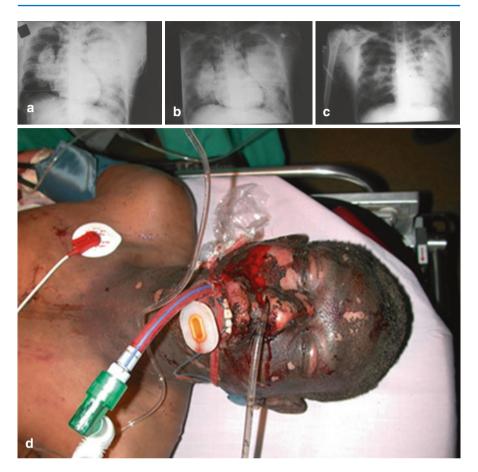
Chest X-rays of a 21-year-old border policeman show development of blast lung injury $(\mathbf{a}-\mathbf{c})$. The man identified a terrorist at the entrance to a hospital and hugged him in order to prevent him entering. The border policeman blew up together with the terrorist. Note typical bilateral patchy lung infiltrates in a classic "butterfly appearance" consistent with blast lung injury (\mathbf{b}) . He also suffered from facial burns. Note blood inside the endotracheal tube, an indicator of severe primary blast lung (\mathbf{d})
